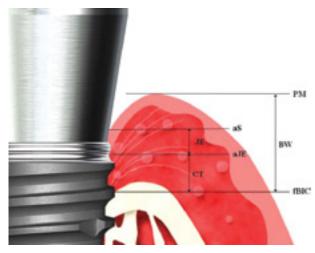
Histometric measurement. PM: marginal portion of the mucosa; aS: apical extension of the sulcus; aJE: apical portion of the junctional epithelium, fBIC: first bone-implant contact; JE: length of the junctional epithelium (aS/aJE); CT: length of the connective tissue (aJE/fBIC); and BW: biological width (PM/fBIC).
